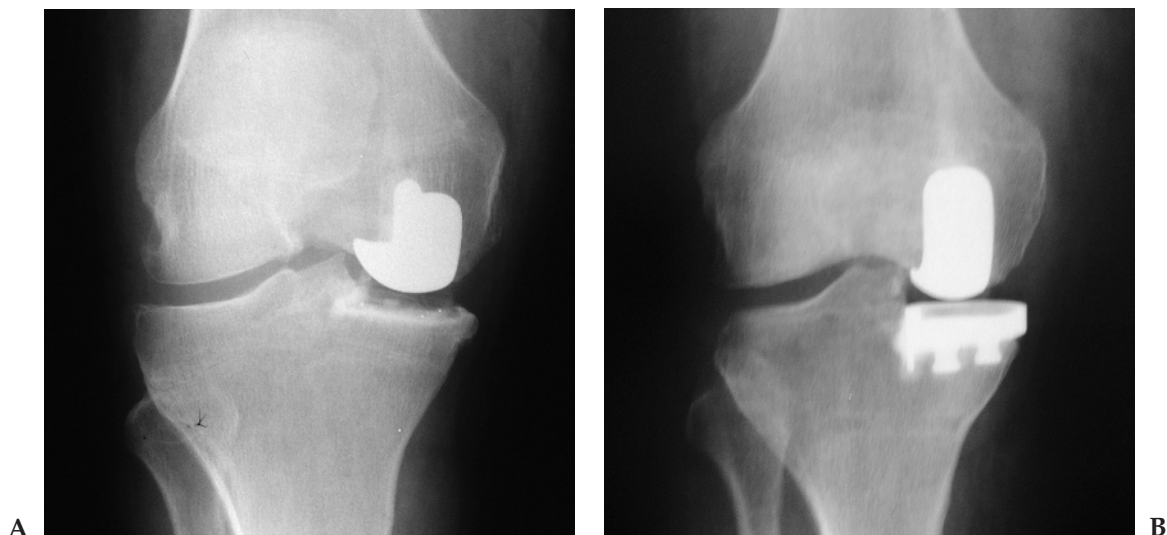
Inlay all-polyethylene versus saw-cut tibial component. AP weight-bearing postoperative radiographs of knee joints exhibiting Ahlback 3 osteoarthritis with complete loss of medial joint space. (A) Limited bone resection and preservation of the medial tibial buttress associated with the use of the inlay all-polyethylene tibial component. (B) More aggressive bone resection and corresponding medial tibial buttress sacrifice required with the use of saw-cut polyethylene designs.
